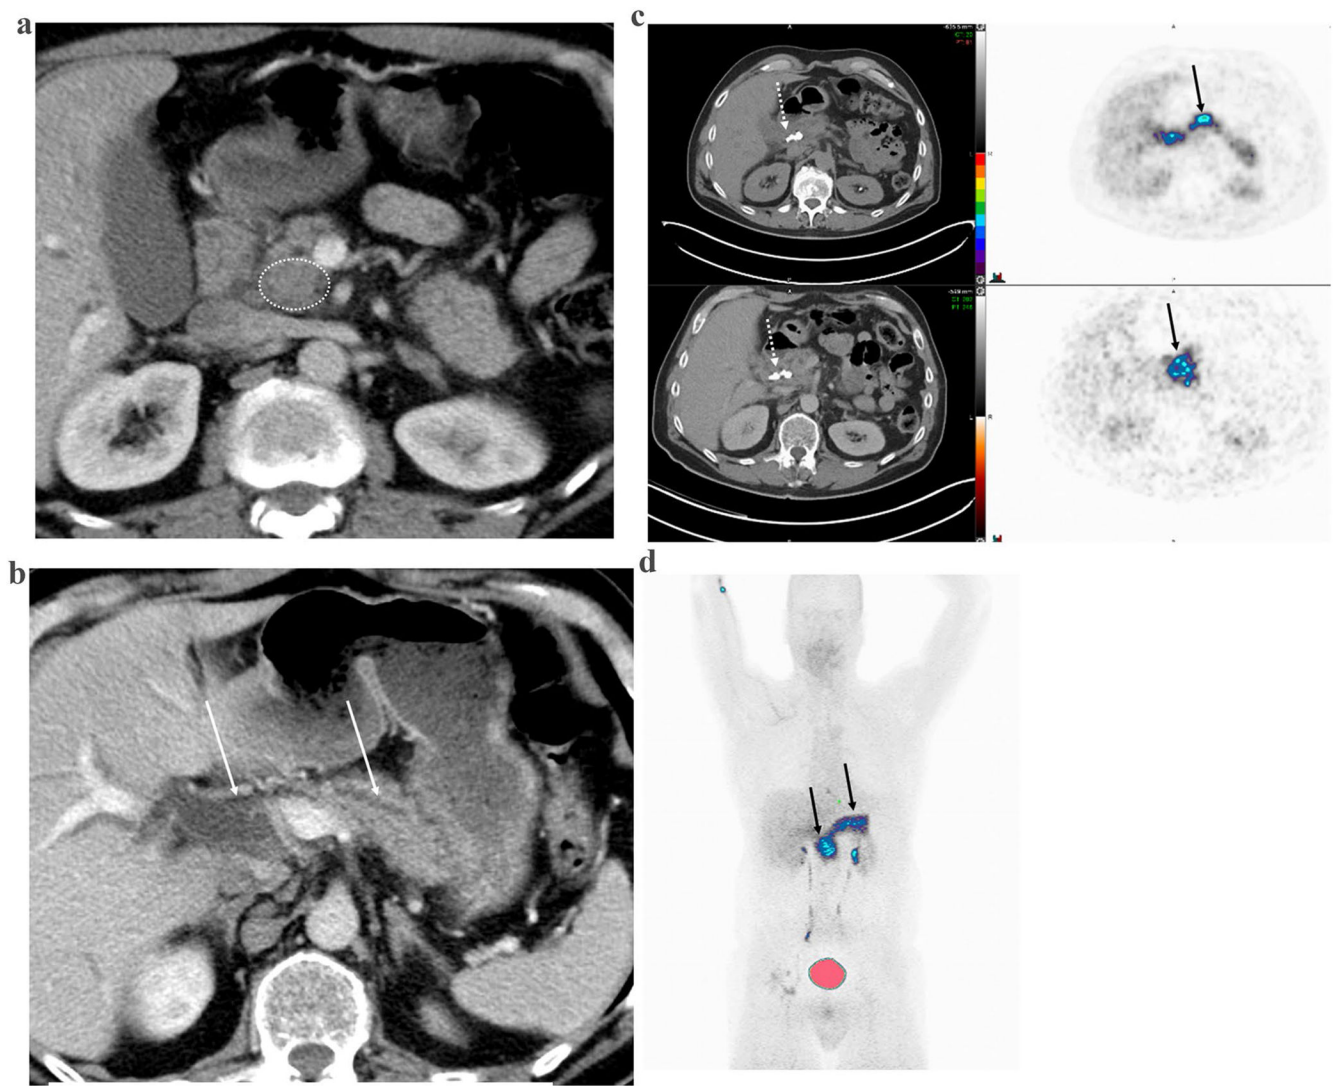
63-Year-old man with an isodense pancreatic head PDA. (A and B) Axial post-contrast portal venous phase images show A a 2.5 cm isodense mass in the pancreatic head (white dashed circle) and B upstream biliary and main pancreatic duct dilation (white solid arrows). C and D Eighteen days after the initial CT and following biliary stent placement (white dashed arrows), the patient underwent a ^{68}Ga -FAPI46 PET/CT as a clinical trial participant. Increased ^{68}Ga -FAPI46 uptake is noted in the pancreatic head mass (SUV 19 and 17 at 15 and 60 min after injection, respectively) and diffusely within the pancreas where there is subclinical post-obstructive pancreatitis (SUV 18 and 16 at 15 and 60 min after injection, respectively) (black solid arrows)
